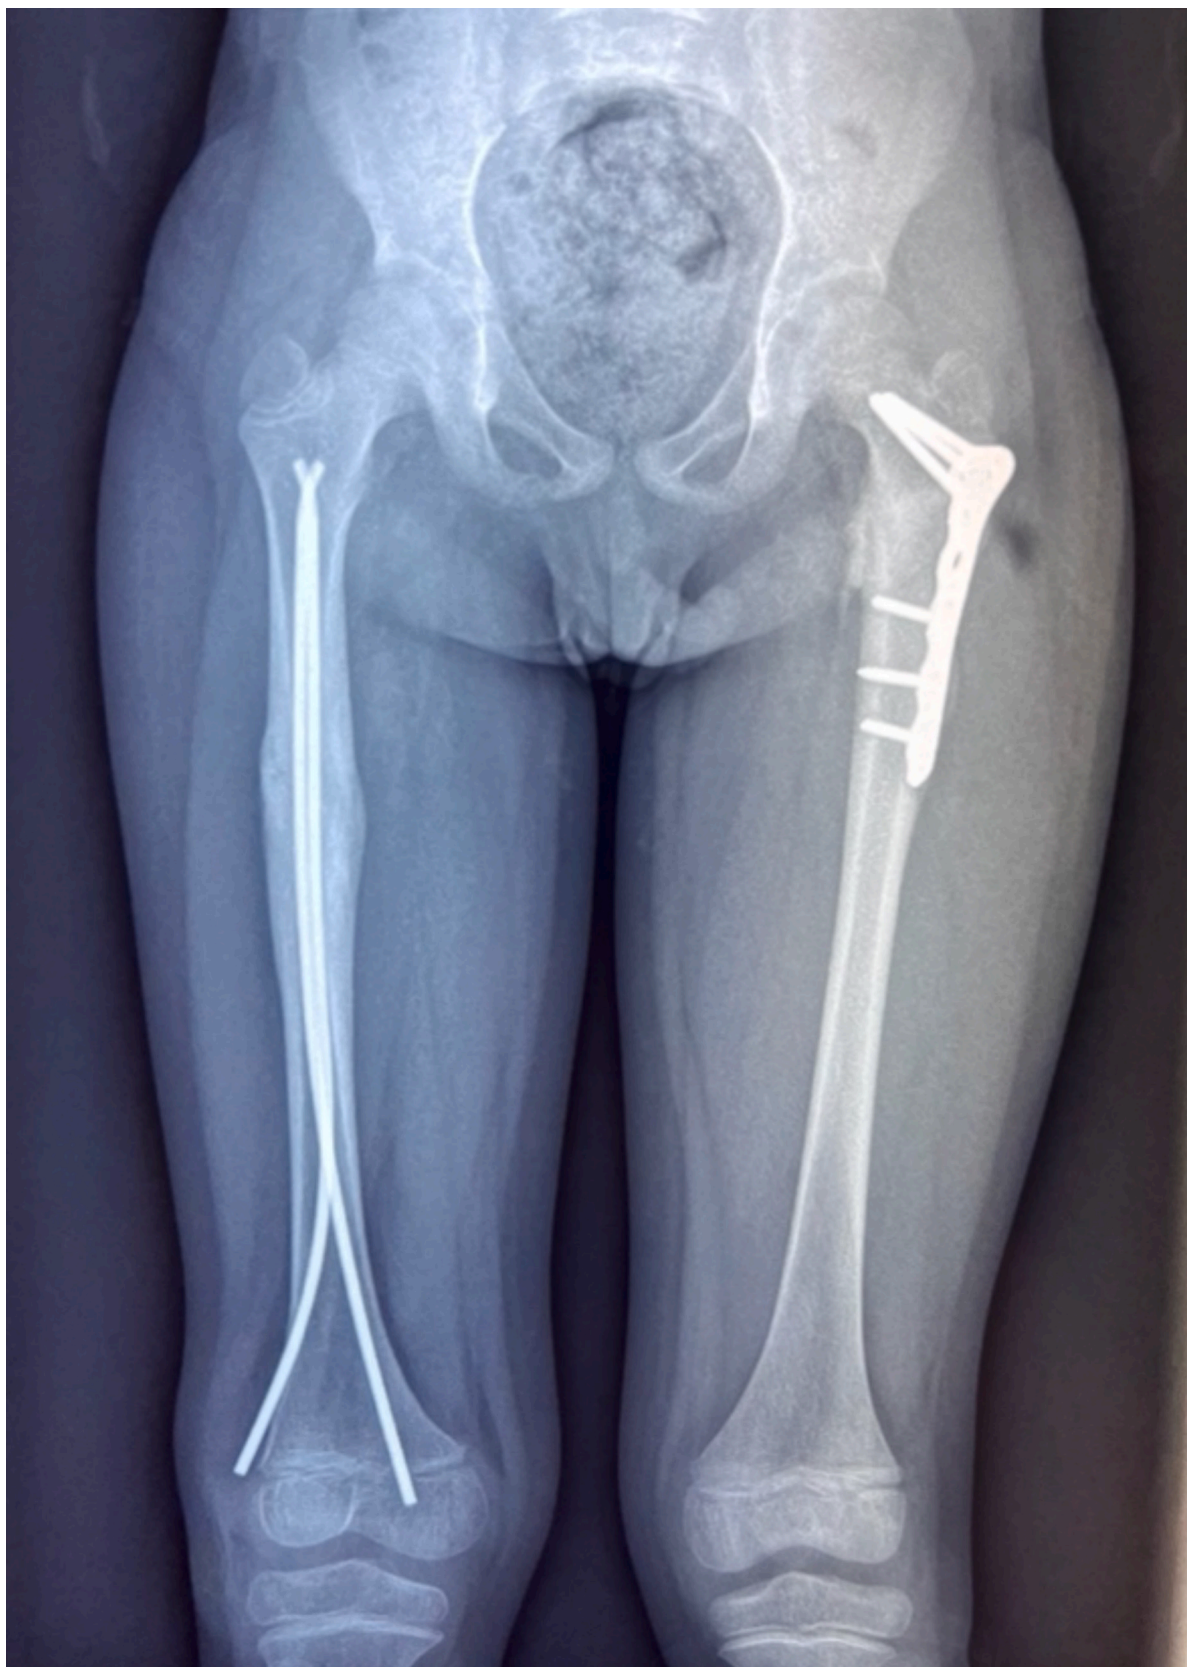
Anteroposterior radiographs of whole femurs three months post operation, with healed fractures.
